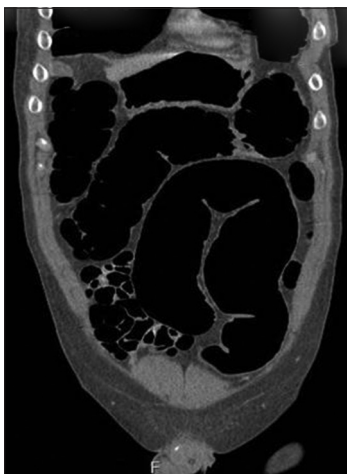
Computed tomography scan abdomen coronal image showing entire large bowel dilatation including rectum
